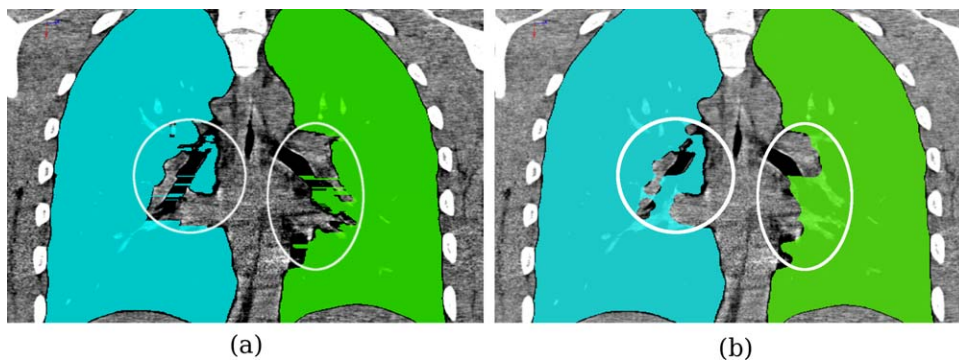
Automatic extraction of lung space in HRCT. a) Raw extraction and b) smoothed lung space. The masks are shown in lightly transparent blue (right lung) and green (left lung) and the ROI are surrounded by circles.
